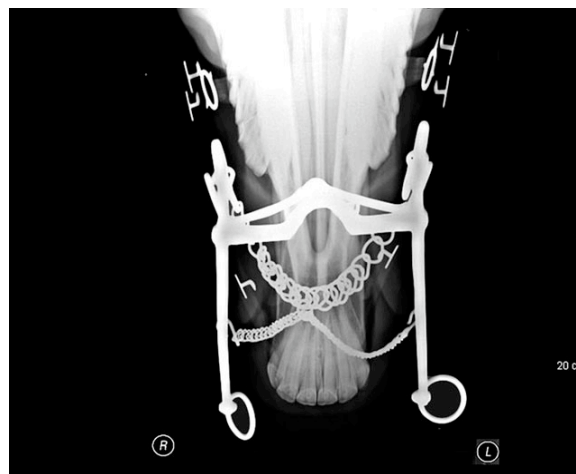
X-ray of a double bridle.
